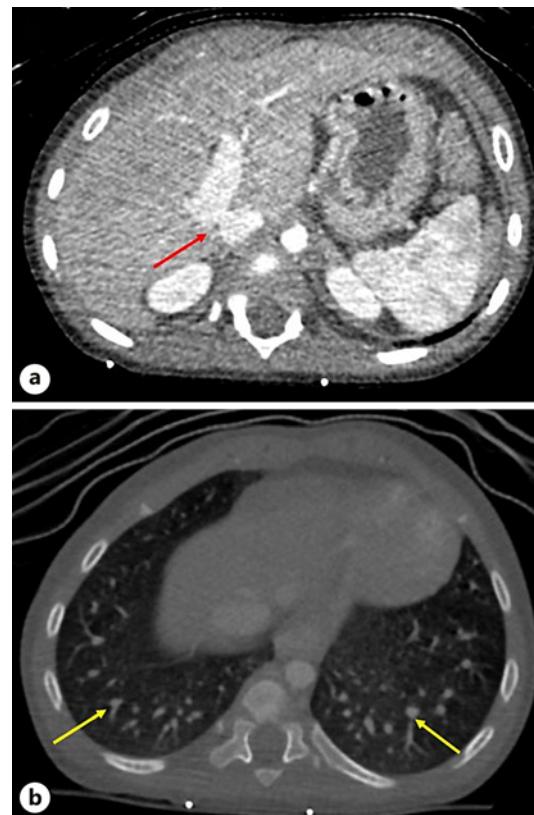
a A computed tomography of the abdomen and pelvis with contrast shows a connection between the right portal vein and inferior vena cava, consistent with a CPSS (red arrow). b Dilated pulmonary artery branches of the peripheral system are seen, suggesting hepatopulmonary syndrome (yellow arrows).
